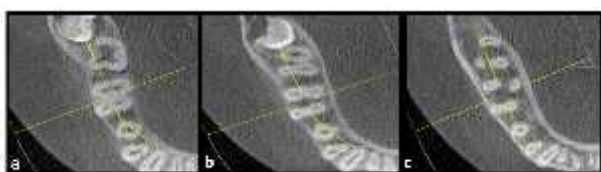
CBCT images at (a)coronal, (b)middle and (c) apical third of 46 respectively
